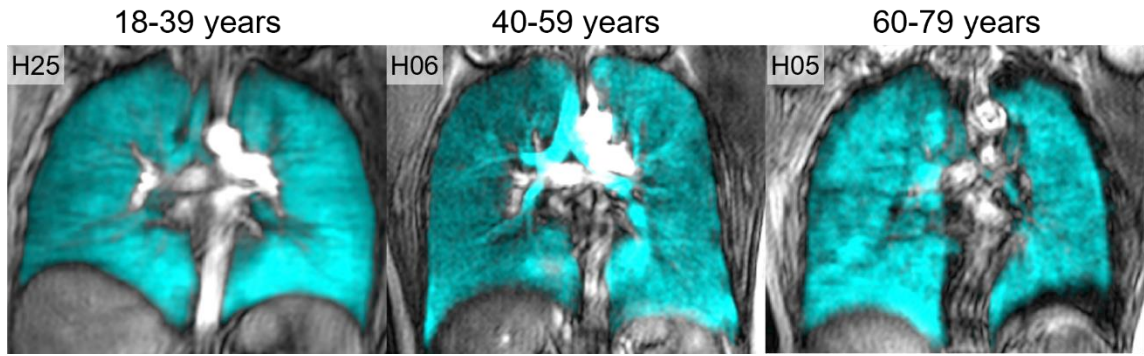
^{129}Xe MRI in healthy participants
